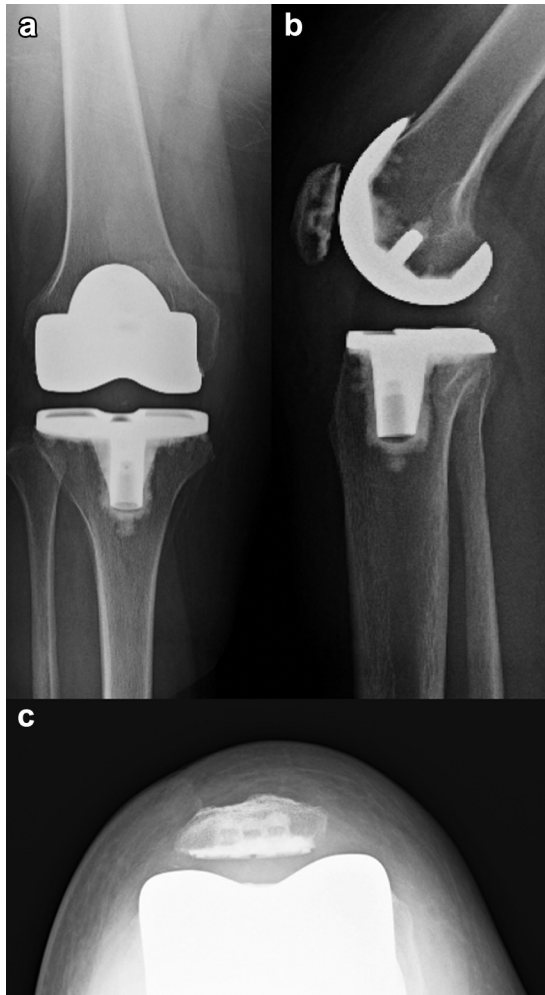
Six-week postoperative radiographs of the patient: (a) anteroposterior; (b) lateral; (c) axial.
